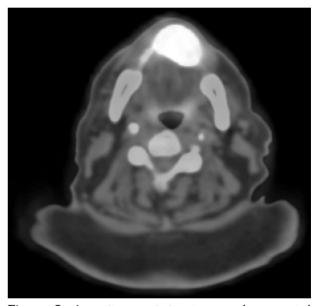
A positron emission tomography-computed tomography scan showing a high fluorodeoxyglucose uptake in lesion of anterior mandible.
